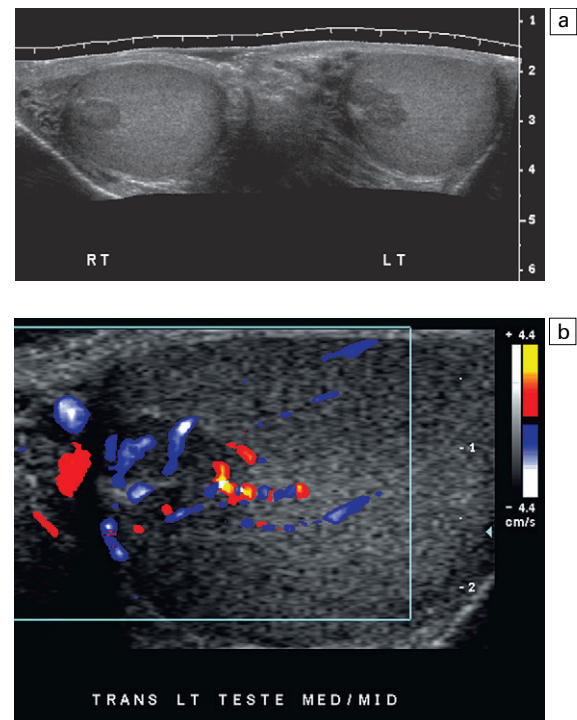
(a) Transverse panoramic view of both testicles. Hypoechoic masses are identified adjacent to the mediastinum of both testes. (b) Colour Doppler image of the left paramediastinal mass shows hyperaemia. Vessels appear to be passing through this region. The patient had a known history of congenital adrenal hyperplasia and these represent benign rests of adrenal tissue.
